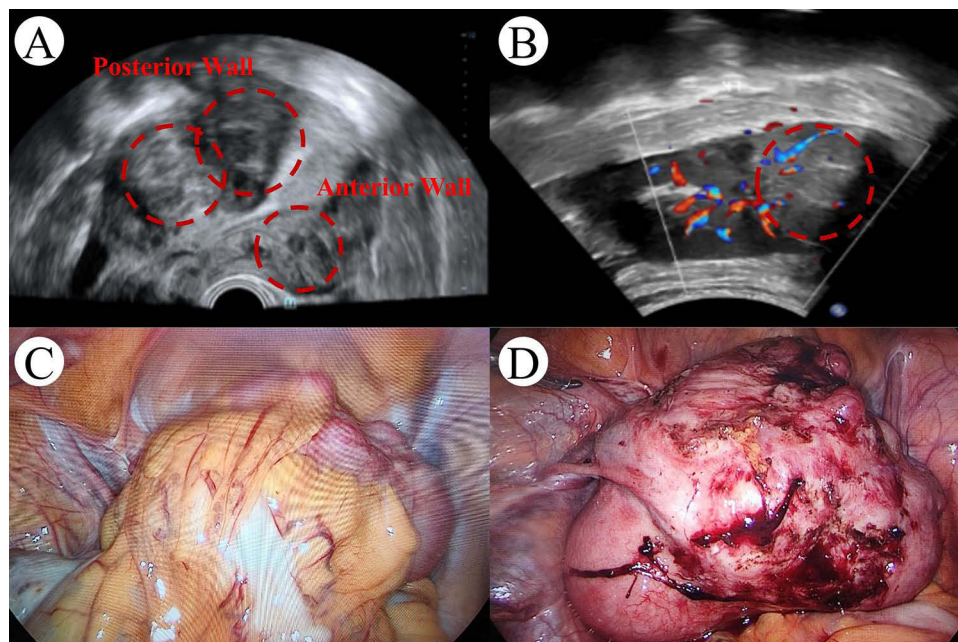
(A) transvaginal ultrasound images of uterus. The red circle indicates the visualization of some of the fibroids. (B) renal ultrasound. (C) intraoperative snapshot showing extensive adhesions between the intestine and the uterus. (D) intraoperative snapshot showing the enlarged uterus with an extremely irregular shape and with more than a dozen protuberances resembling fibroids.
